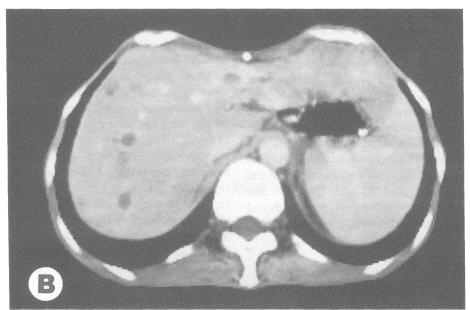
CT scans in case 2. A before operation. B 5 months after the occlusion therapy.
